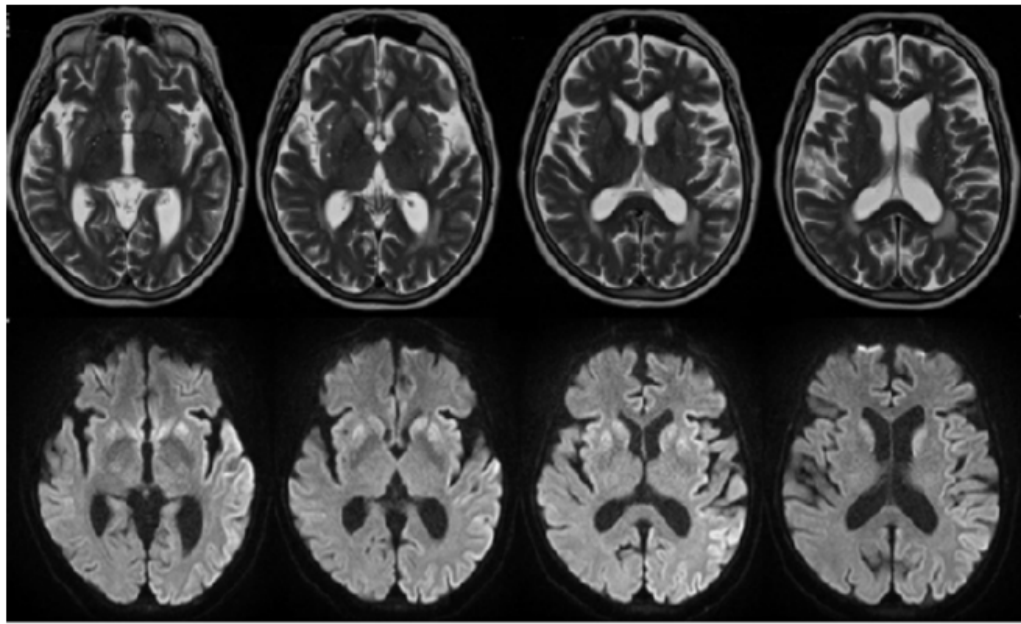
MRI demonstrating hyperintensity of the caudate and putamen and T2/FLAIR hyperintensity with subtle involvement of the basal ganglia.
